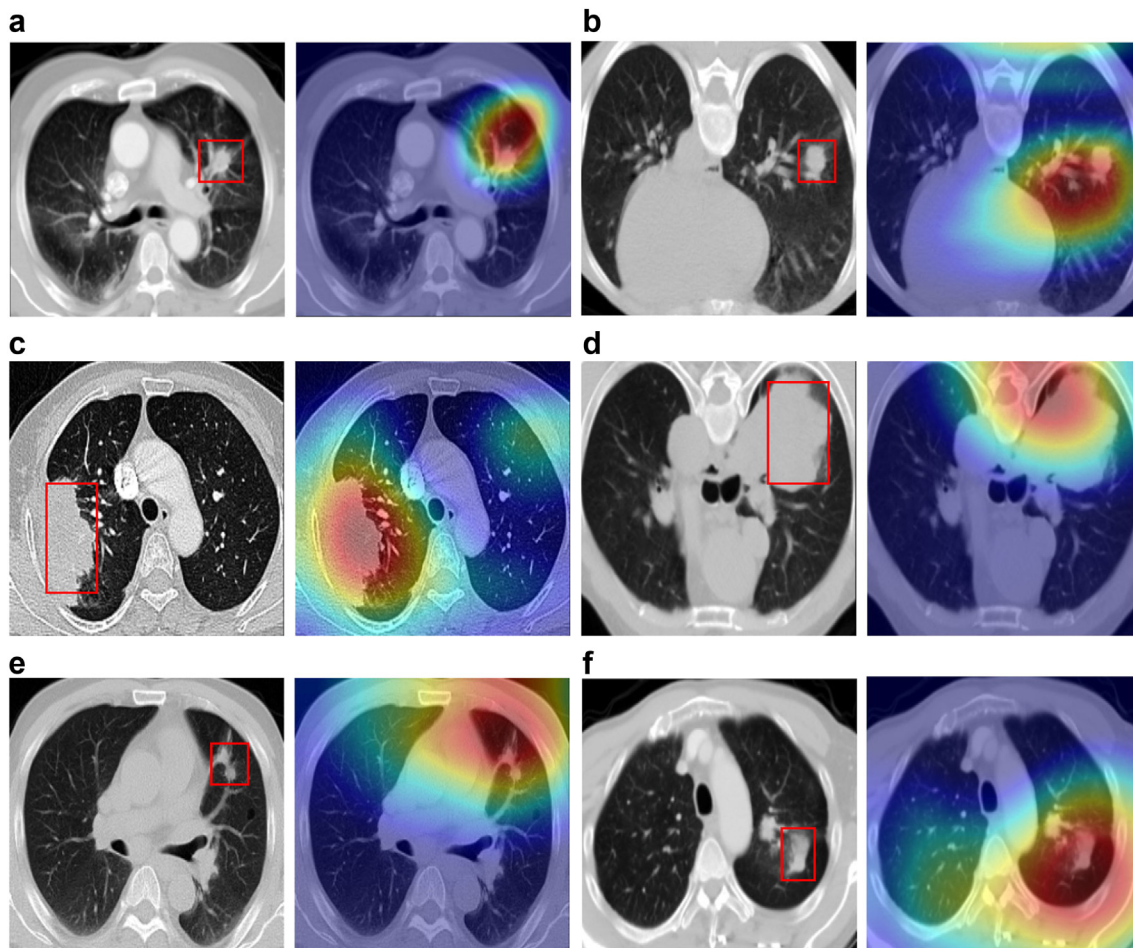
Network visualization and interpretation. Visual explanations of the areas in the CT images identified by IPES. The first column in subfigure is the original CT image, the second column in subfigure is the saliency map overlaying the original CT image. In each original CT image of (a–f), the lung tumor has been marked with a red bounding box.
